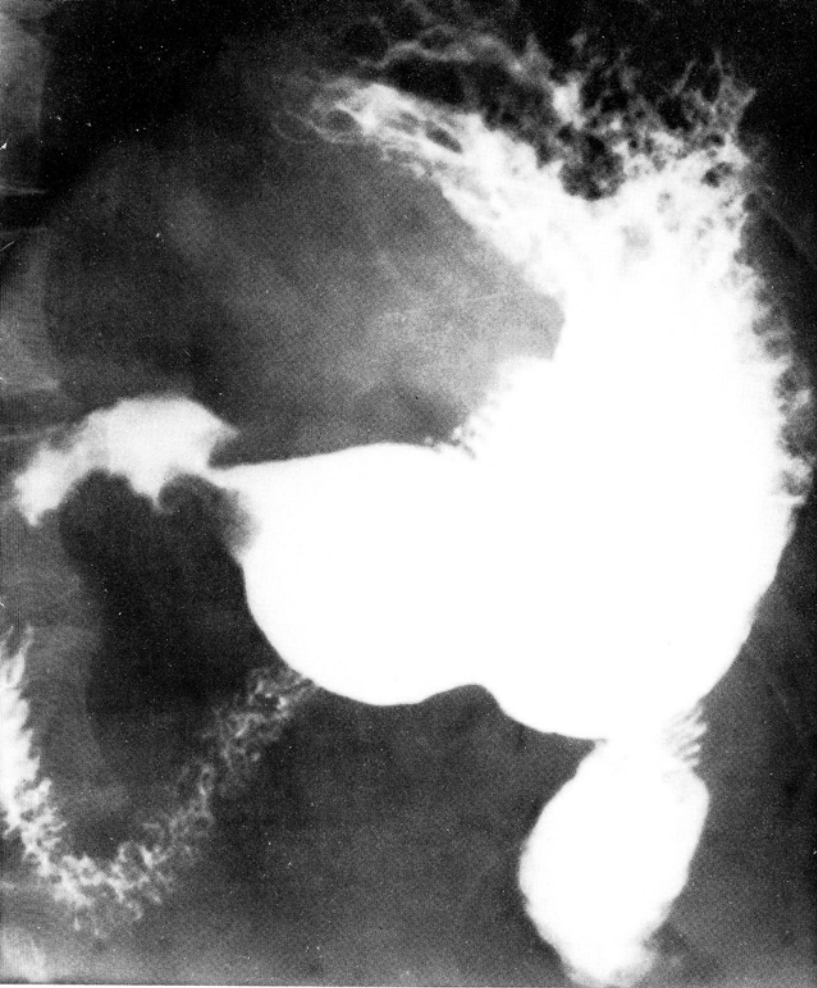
Roentgenograms of the stomach (1956) showing defect caused by ectopic pancreatic tissue.
